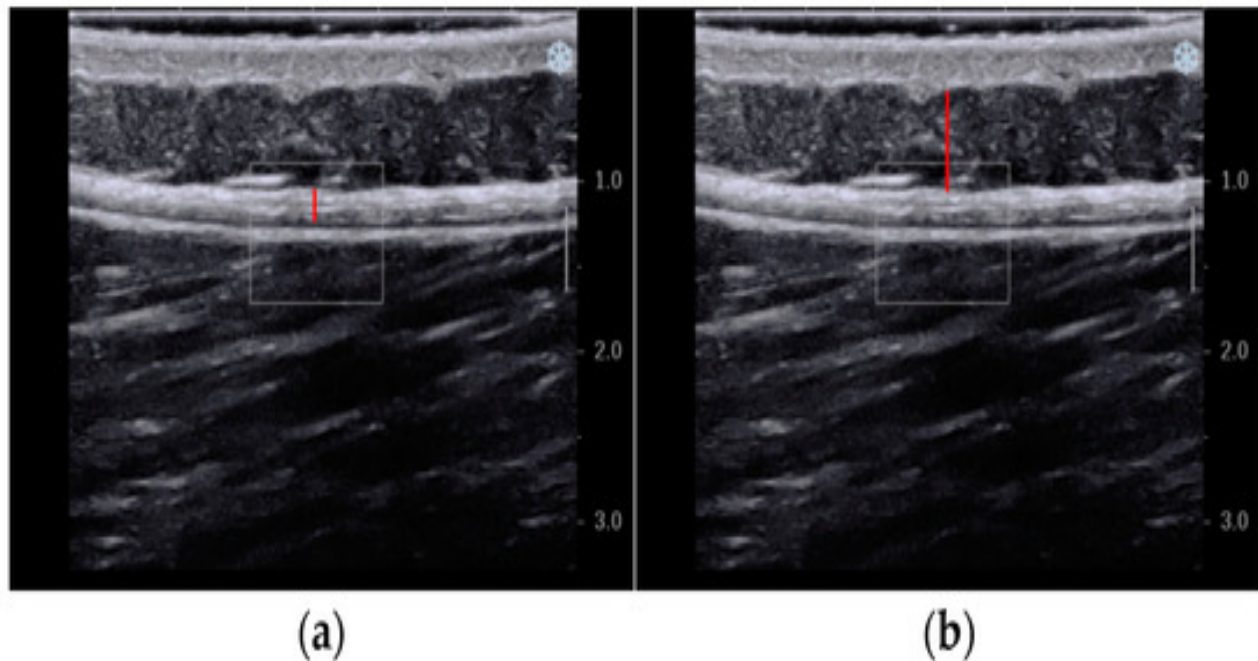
Ultrasound image of one participant's lower back. Image a indicates with a red line the layers of the TLF. Image b indicates with a red line the loose connective tissue of the Subcutaneous layer above the TLF. (Devantéry et al., 2023).
